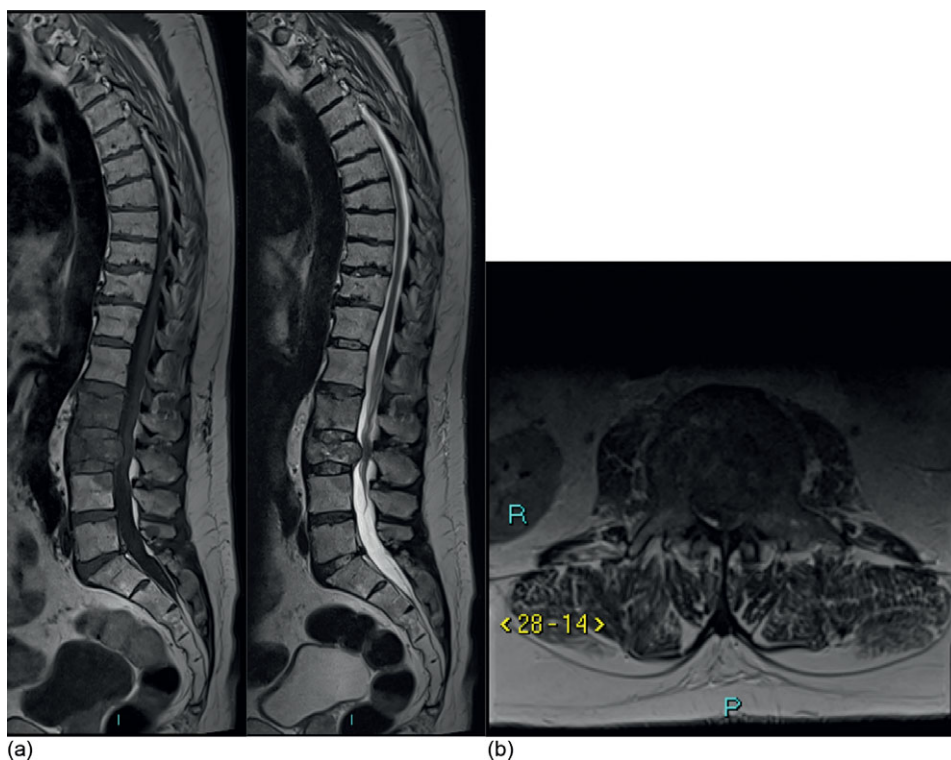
(a) T1 and (b) T2 sagittal whole MRI spine images and (c) T2 axial cut at area of interest
